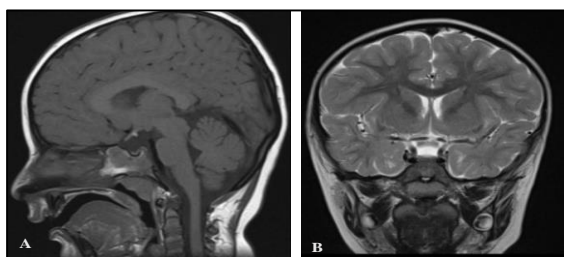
(A and B): Pituitary stalk interruption syndrome in a 6-year-old male child presenting with hypoglycemia, short stature, seizures and DD. T1W sagittal MR image showing posterior pituitary bright spot in the region of hypothalamus, abutting the optic chiasma (ectopic) and anterior pituitary is small in size measuring 2.4 mm craniocaudally and volume of 43 cc. T2W coronal MR image showing absent pituitary stalk.
